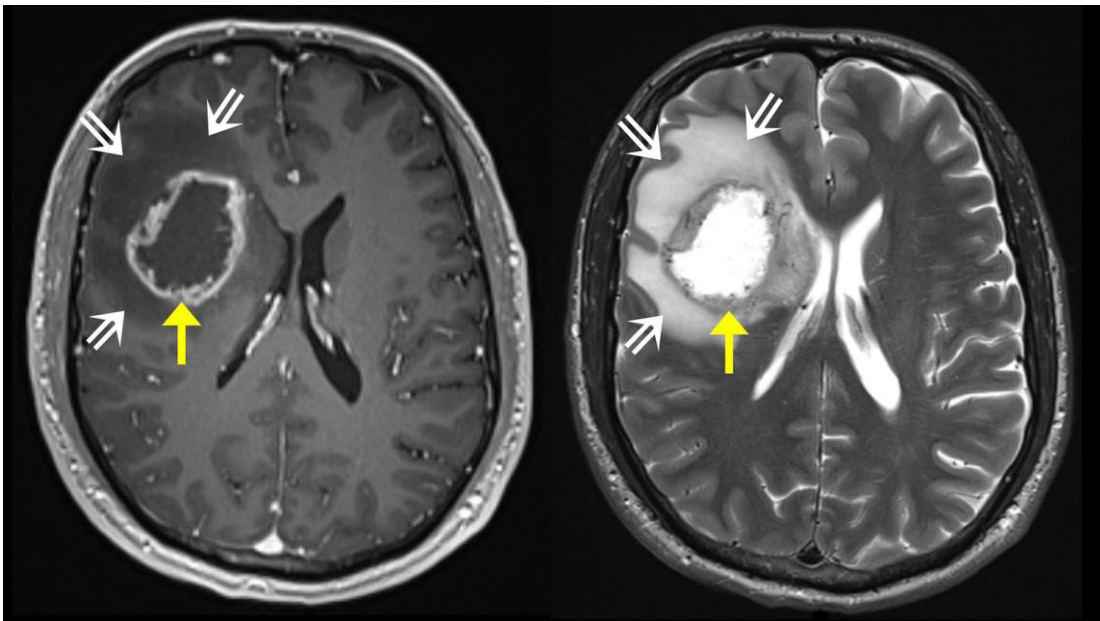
MRI images of Glioblastoma. Axial T1- sequence with contrast(left) and T2- sequence(right). White arrows show cerebral Edema whereas yellow arrow shows tumour areas. (50)
